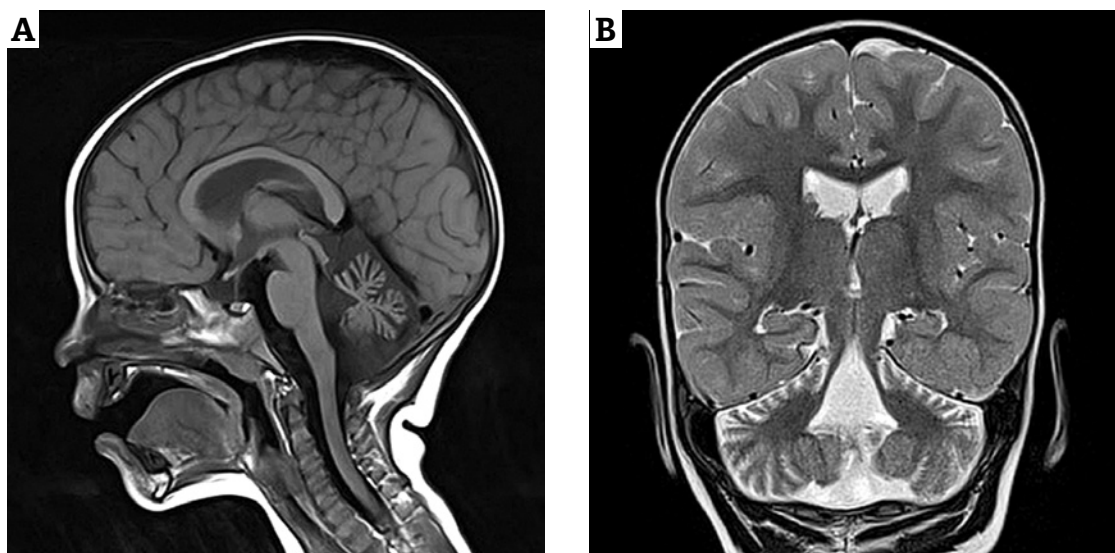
Magnetic resonance imaging head scan of the 2-year-old patient with visible atrophy of the cerebellar vermis and mild atrophy of the superior cerebellar hemispheres. A) Sagittal section. B) Frontal section
